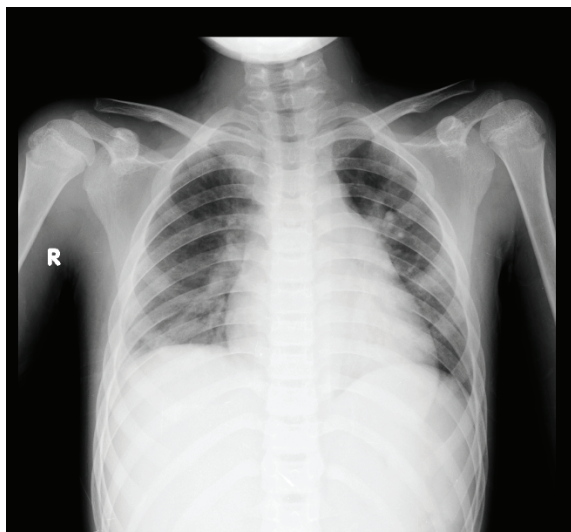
A: Chest x-ray at transfer to our medical centre showing right lower lung infiltration
